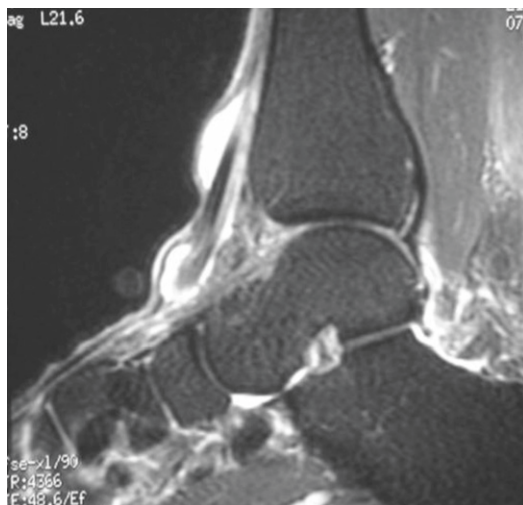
Sagittal T2-weighted MRI sequences of a ruptured tibialis anterior tendon demonstrating increased fluid signal within the tendon sheath and retraction of the tendon
